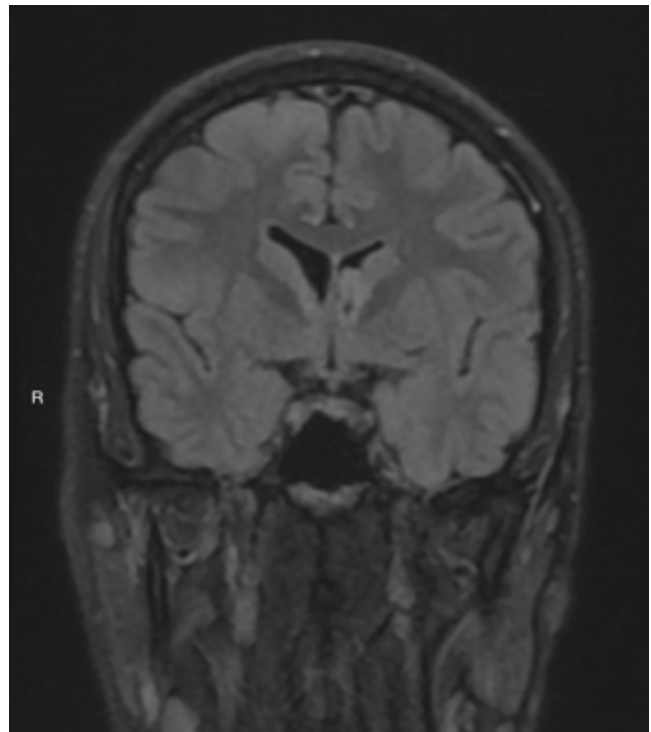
Nodular hyperintense lesions in lateral ventricles and peritrial level in T2 Coronal FLAIR MRI
